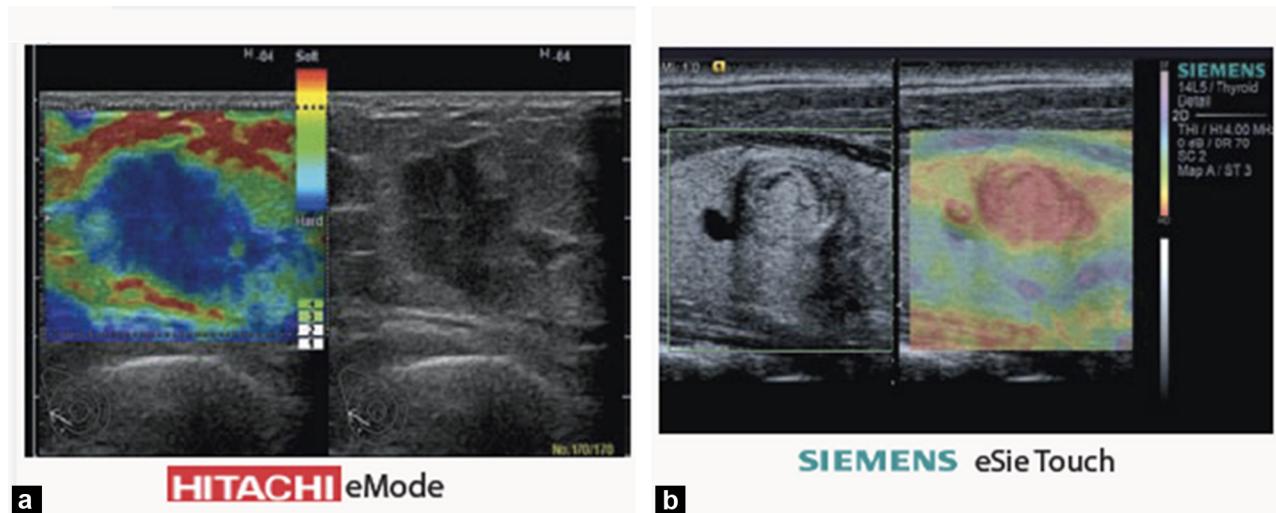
Hitachi with the “eMode” commercialized in Hi Vision 900 ultrasound machines and Siemens with its “eSie Touch Elastography Imaging” mode in Acuson Antares ultrasound machines are the first commercial versions of static elastography: a: strain image of a carcinoma; b: strain image of the thyroid.
